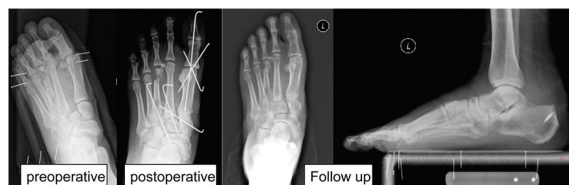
Radiographs showing initial and postoperative treatment of Lisfranc joint fracture and dislocation and avulsion fracture of Achilles tendon insertion.
